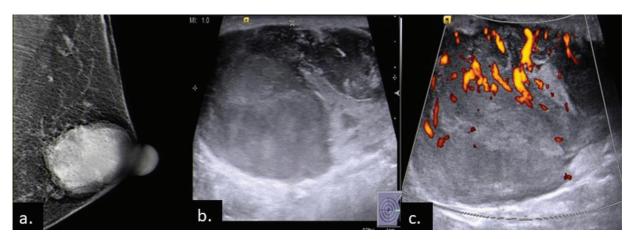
A male patient presented with a large round dense mass on mammogram (a), which was thought to be a phyllodes tumor. Ultrasound revealed a large mixed echogenic mass with intense vascularity (b and c), which was assigned BIRADS 4C category. Left mastectomy revealed high-grade primary sarcoma of breast . BIRADS, Breast Imaging and Reporting Data System.
